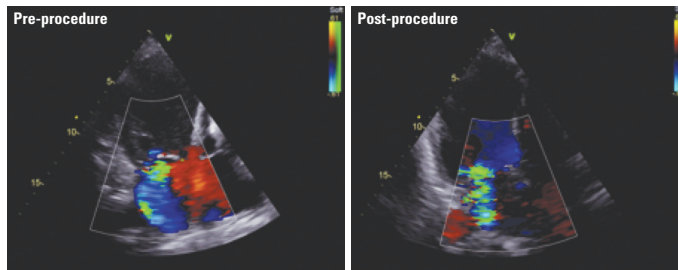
Echocardiography, pre-procedure and post-procedure.
